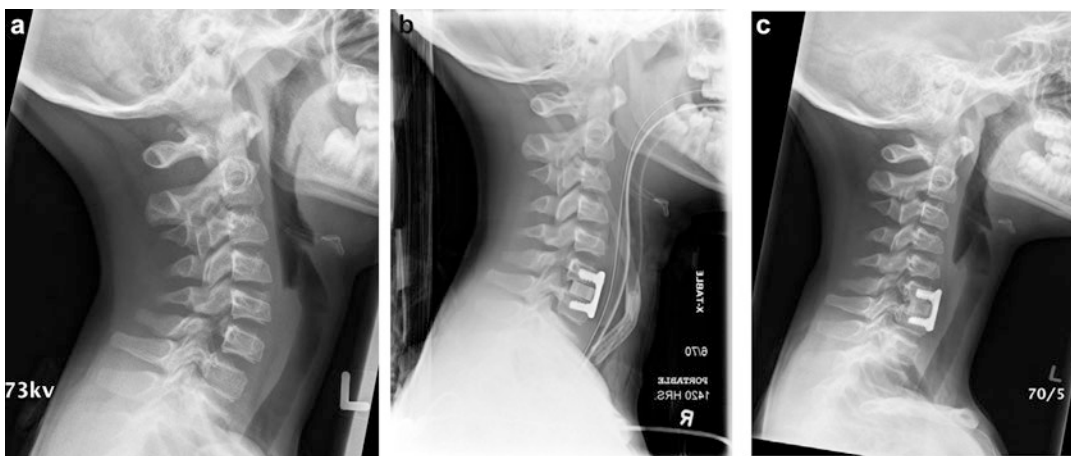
(a–c) 8-year-old male with C6 pars defect and C6 on C7 anterolisthesis presented with neck pain after soccer-related injury. (a) X-rays on presentation showing
